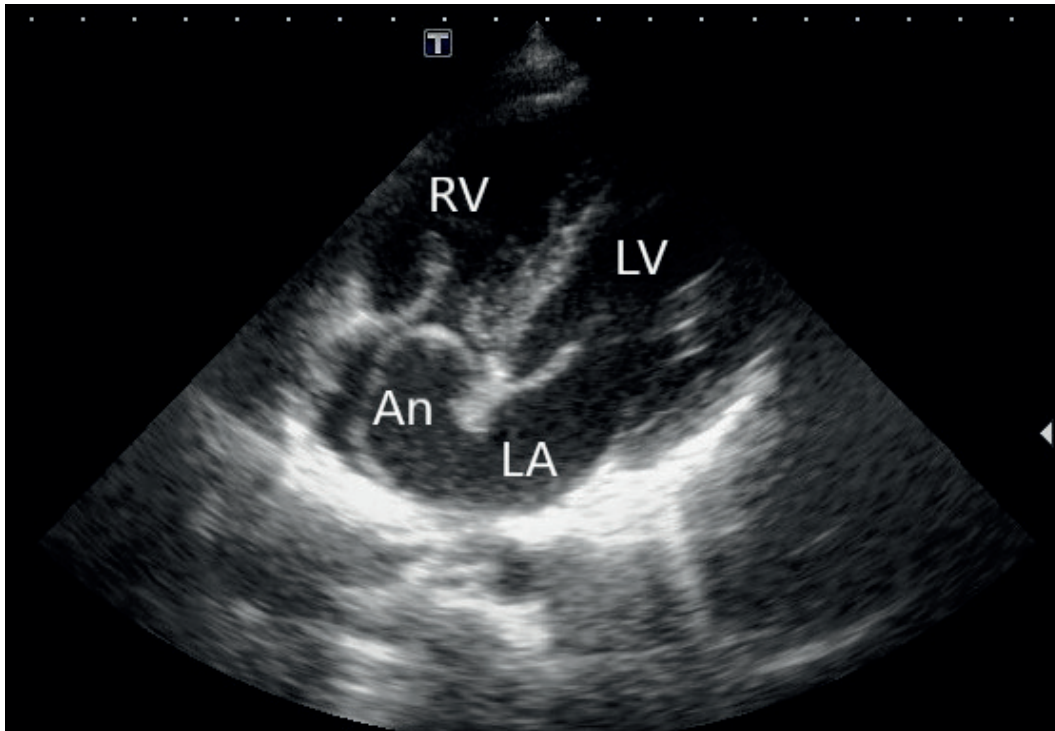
Apical four-chamber view. An – atrial septum aneurysm protruding from left to right atrium
